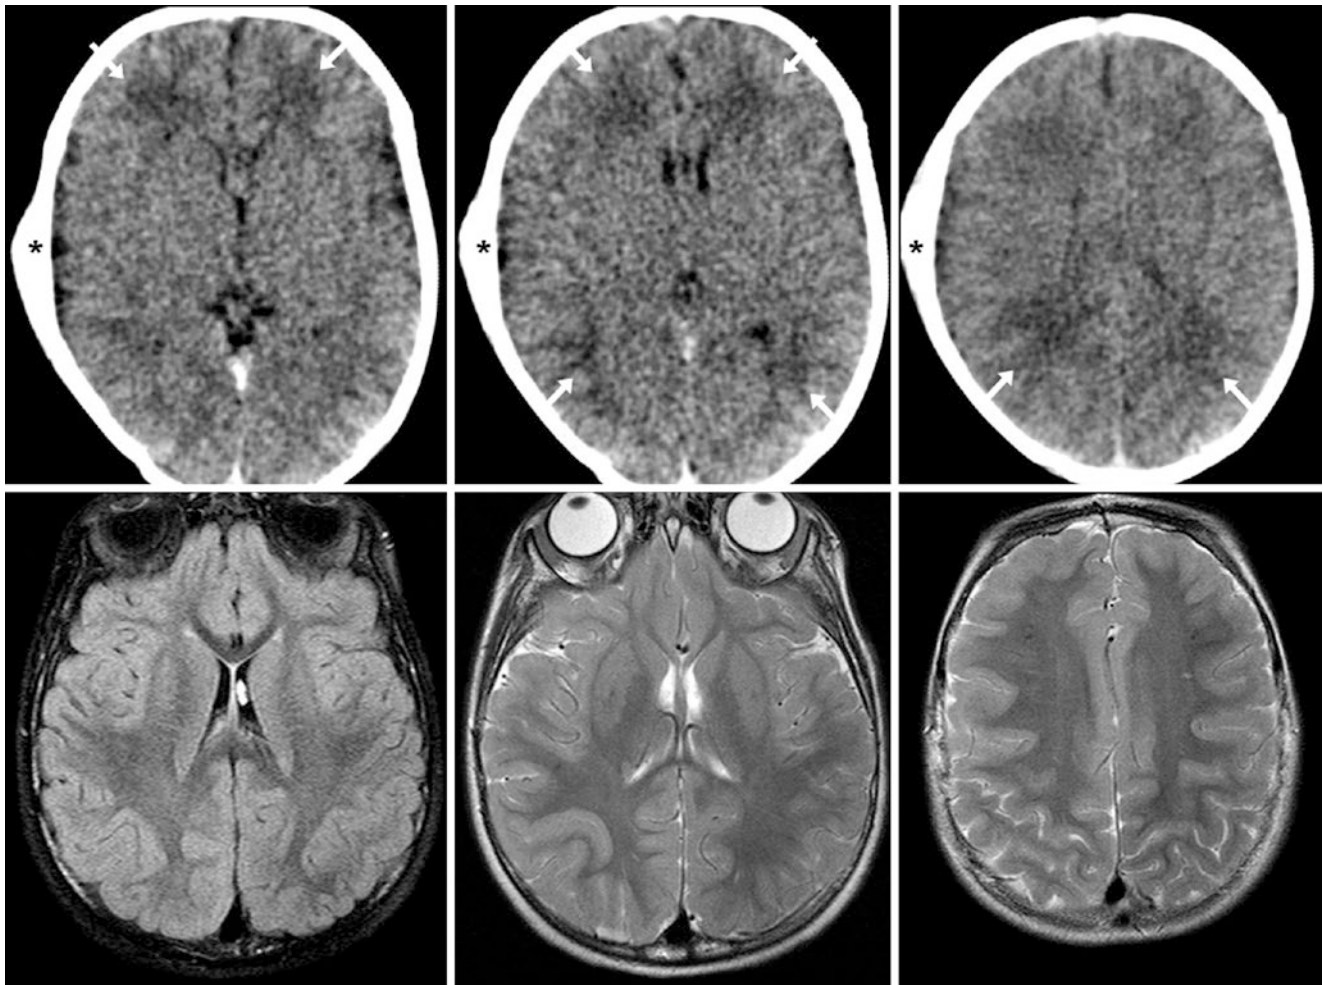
An 8-day-old term neonate had a nondisplaced right temporal skull fracture and an overlying cephalohematoma (*asterisk*) after being dropped, without intracranial hemorrhage on a nonenhanced CT (NECT) (*top row*). There were patchy, hypodense areas throughout the periventricular
